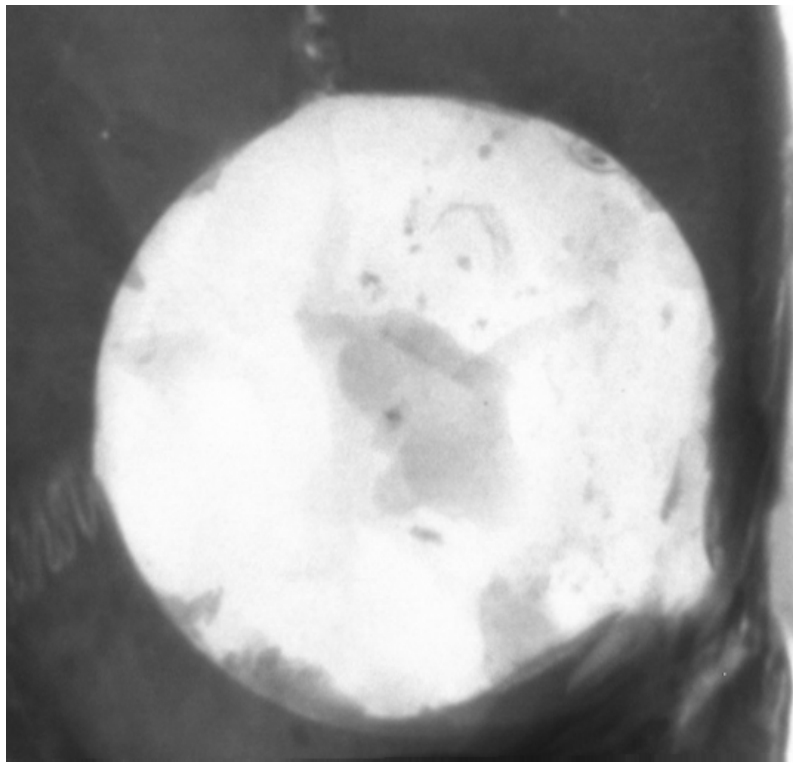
Micro CT image of Empty / negative control at 4 weeks
